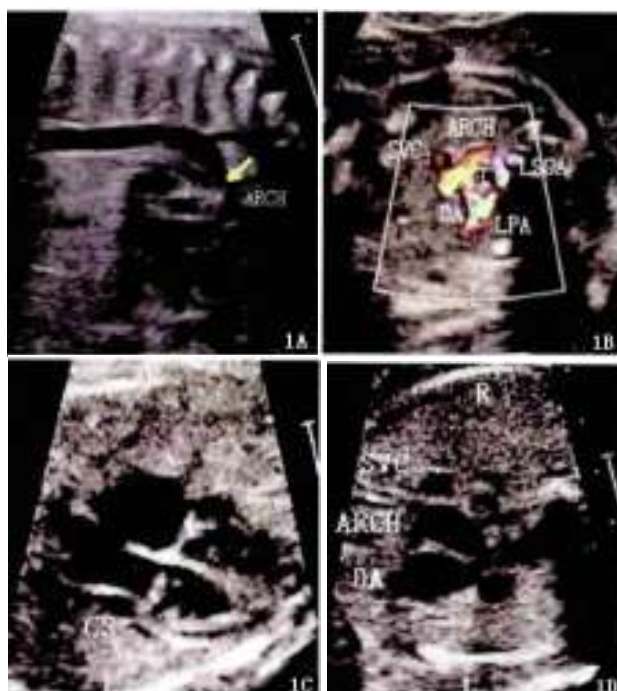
Echocardiography of typical great vessel malformation. A) Echocardiography suggested stenosis of aortic arch behind the left common carotid artery and left subclavian artery. B) Echocardiography suggested that the trachea was wrapped by the right aortic arch, right duct arch and left subclavian artery in a C-shape. C) Echocardiography suggested persistent left superior vena cava, and there were left superior vena cava, arterial duct, aortic arch and superior vena cava in 3VT view from left to right (in oVo shape). D) Echocardiography suggested arterial duct circuitry. R: right; L: left; SVC: superior vena cava; LSA: left subclavian artery; ARCH: aortic arch; DA: Ductus arteriosus; T: trachea; CS: coronary sinus; PA: pulmonary artery.
